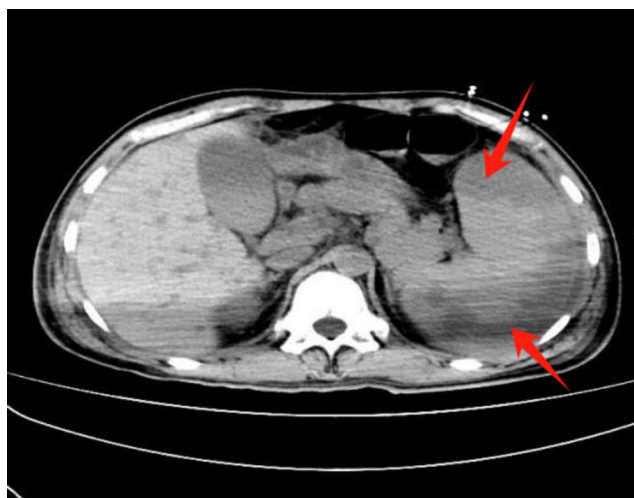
Abdominal CT suggests multiple low-density masses under the pericardium at the outer edge of the spleen with well-defined borders (arrow).
